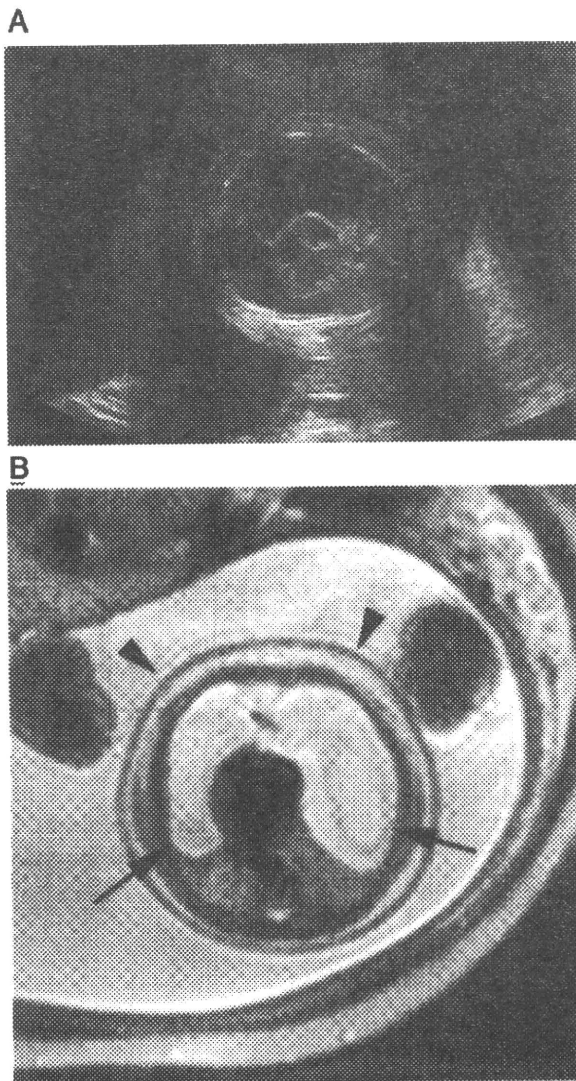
A, Fetal ultrasound at 29 weeks of gestation shows a large cystic mass and compressed heart and lung. B, Fetal magnetic resonance imaging (single-shot turbo spin echo sequence: repetition time, 900 milliseconds; echo time, 84 milliseconds) obtained in an axial plane at 29 weeks gestation. Axial views revealed a large cystic lesion in the fetal thorax (arrow) compressing the lungs and the heart. Skin edema was present (arrowhead).
